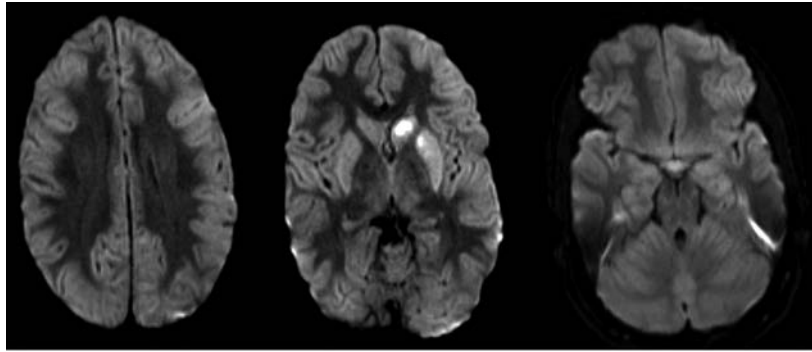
MRI of a post-arrest patient demonstrating diffusion restriction in the cortex and basal ganglia.
